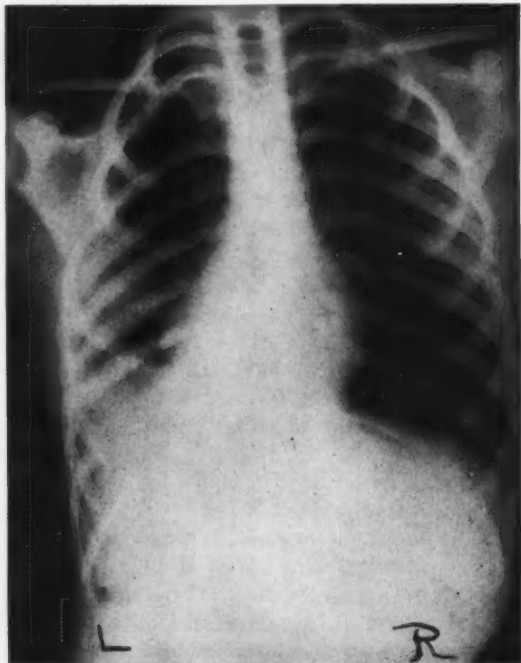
Post Thoracotomy x-ray showing absence of both the mass and the fourth rib on the left.
